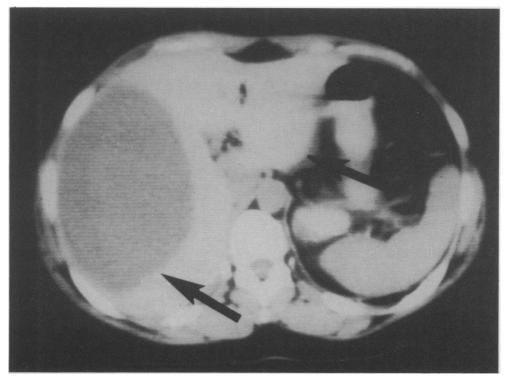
CT scan of abdomen. Arrows indicate tumours in the liver and the anterior mediastinum.
